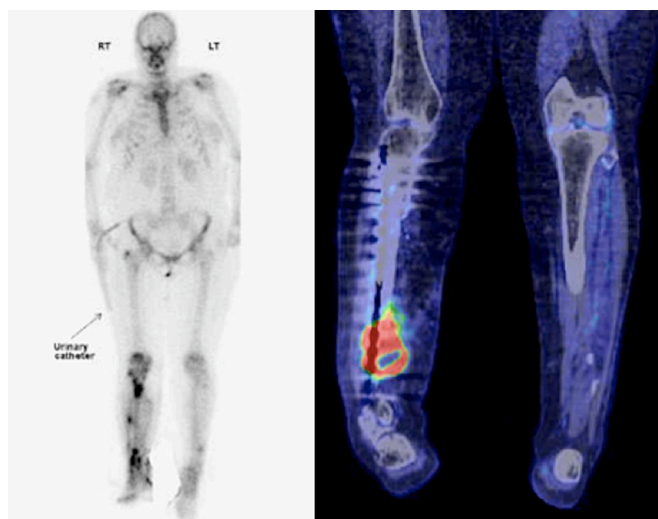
(Left) Technetium-99 nuclear medicine scan demonstrating multi-focal uptake within the right tibia. (Right) PET scan demonstrating an FDG avid mass enveloping the anteromedial aspect of the right distal fibula.
